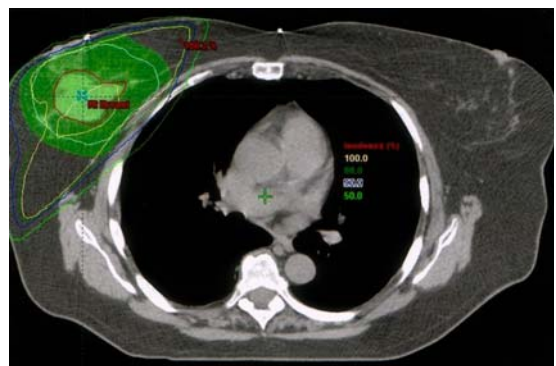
Treatment planning images at the same level of the breast following lumpectomy for partial breast radiotherapy. The lumpectomy cavity as contoured on computed tomography (CT) (a) and with calculated isodose coverage with multi-field, noncoplanar intensity modulated irradiation (b)
